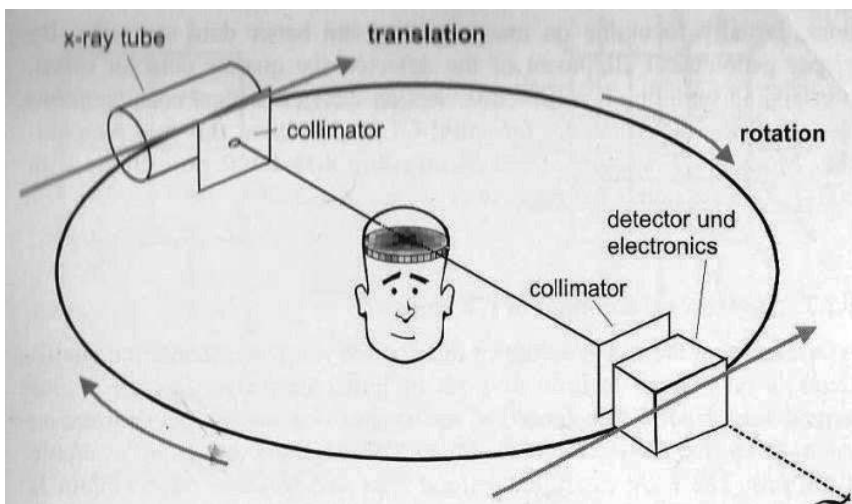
In a single plane, perpendicular to the scanning subject, the x-ray tube, and detector acquire attenuation values 360 degrees around the scanning subject (thus the scanning subject is the axis of rotation). This allows a single 'volume' slice to be obtained. Slices can be combined to form a 3D image visualised from any angle. *image adapted without consent*[14]
